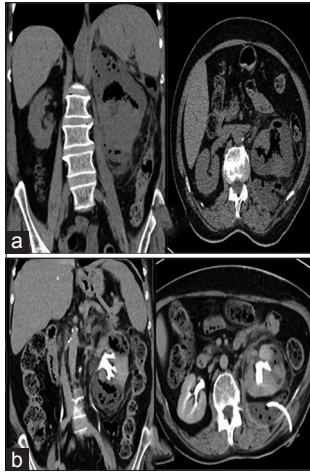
(a) Noncontrast computed tomography (CT)-kidneys, ureters, and bladder (KUB) suggesting Class 3B emphysematous pyelonephritis involving the left kidney with gross peri-renal collection. (b) Contrast-enhanced CT-KUB shows destruction of the upper and lower pole with spared middle pole
